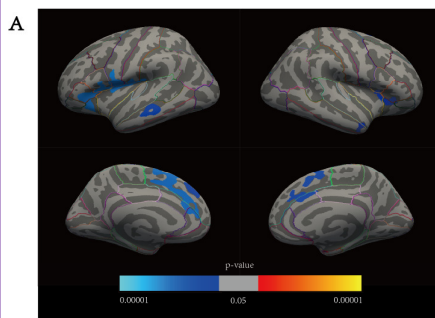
CHRs showed a steeper rate of gray matter loss in bilateral frontotemporal and right caudal anterior cingulate areas than HC. Non-responders showed more pronounced CT reduction than responders in bilateral superior frontal cortex.
